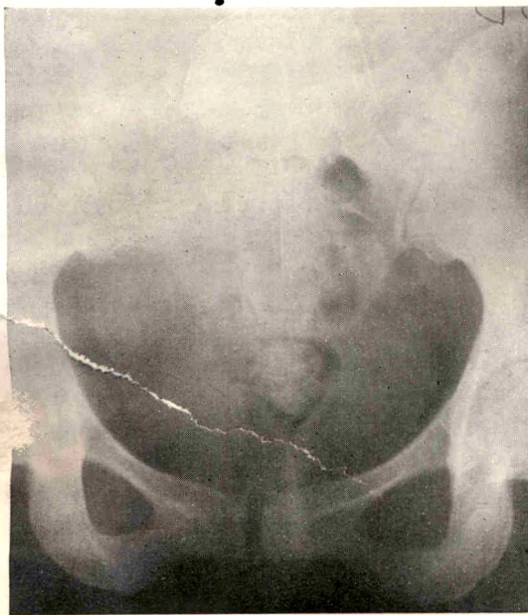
This patient (see also Fig. 7) was suffering from a sacroiliac subluxation and relaxation. The roentgen appearance of the sacroiliac joints themselves is not remarkable. But the left pubis is higher than the right, and there is an increase in the spacing between the pubes.
